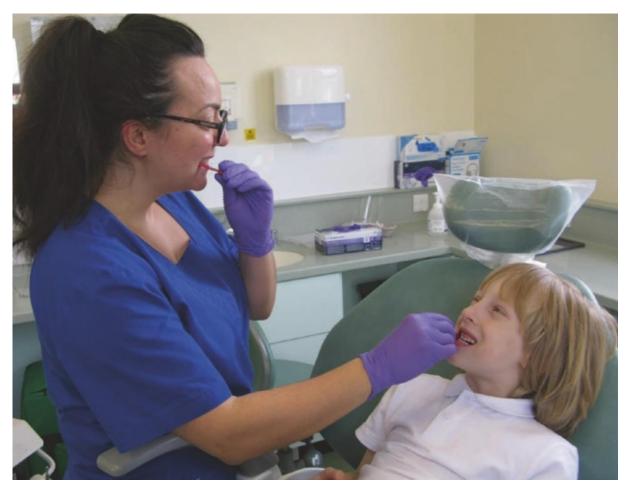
Modelling used to demonstrate the placement of bitewings. In this scenario, the dentist is the model(4).
